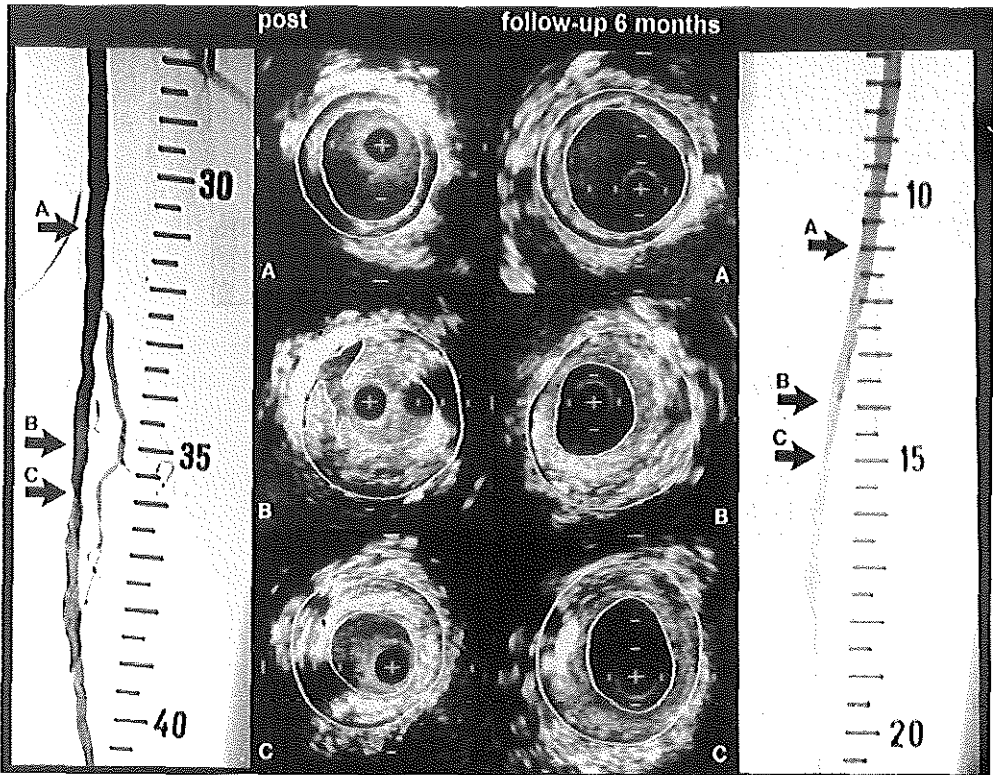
Angiograms and corresponding intravascular ultrasonography cross-sections (levels A, B, C) obtained from a patient after percutaneous transluminal angioplasty of the femoropopliteal artery (left) and at 6 months follow-up examination (right). The ultrasonography cross-sections are contour traced off-line for lumen area (inner contour) and vessel area (outer contour). Level A is obtained at the proximal reference site, and levels B and C are obtained at the treated sites. Plaque area increase was seen in all levels; lumen area increase (levels A and C), and lumen area decrease (level B) was determined by the type of vessel area change. Media rupture and dissection seen after intervention (level B, solid arrow) were not encountered at follow-up examination. At level C, hard lesion (open arrow) was seen both at intervention and at follow-up examination. Note that the guidewire present in the left panel results in a dropout of 30 degrees. += catheter; calibration = 1 mm.
